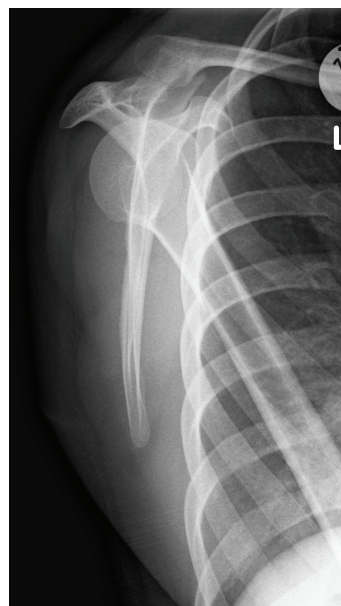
Left scapula target radiograph after arthroscopic trimming: completely removed prominence of the superomedial scapula part.
